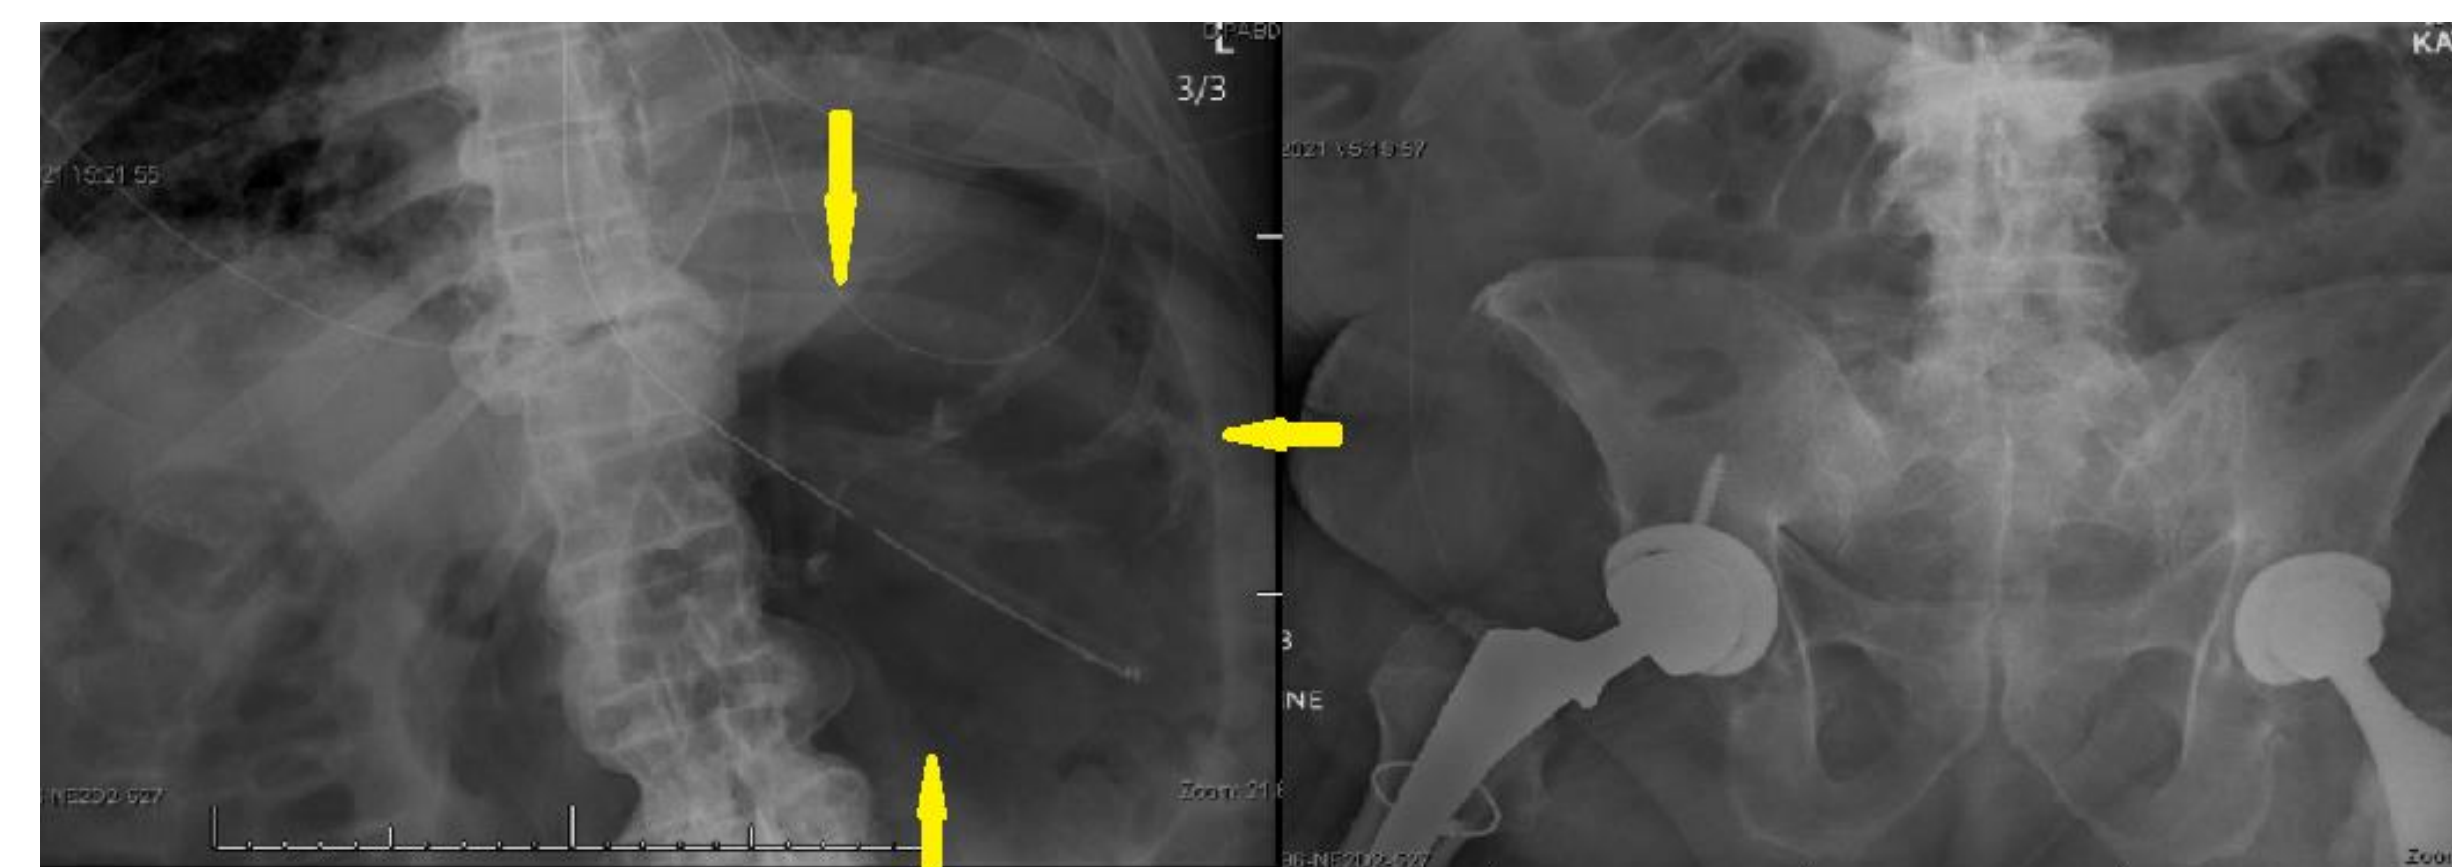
Abdominal radiography demonstrated no obstruction. Yellow arrows mark gastric distension.
